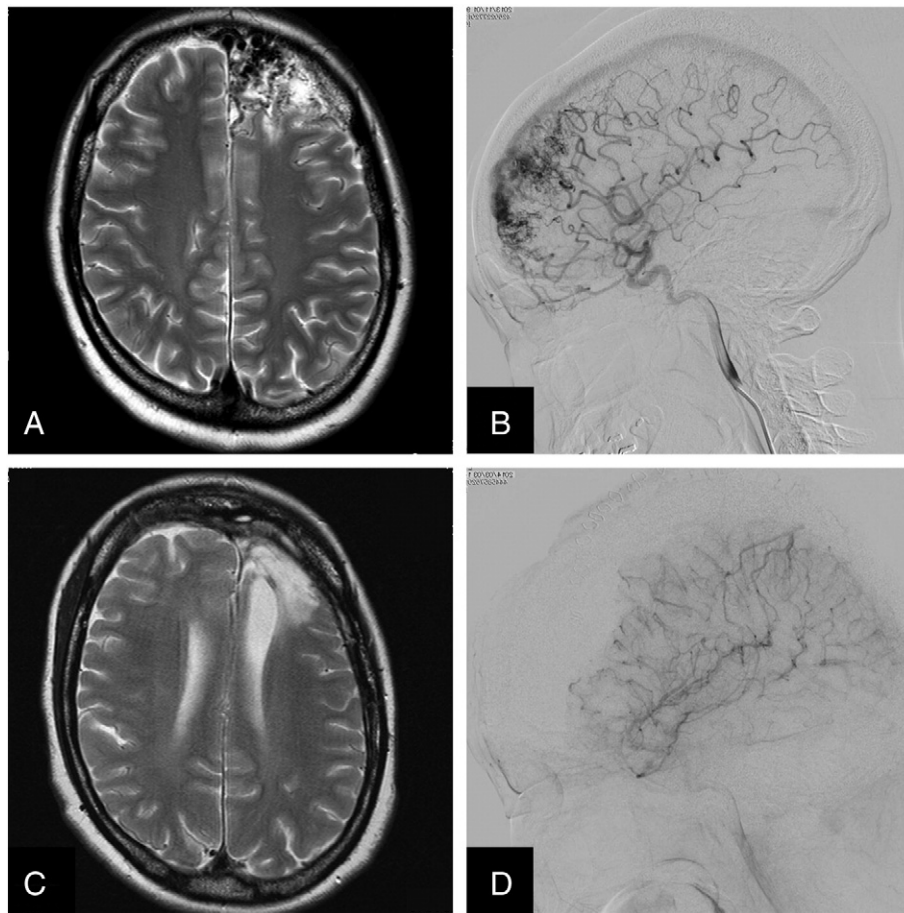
Comparative pictures of preoperative and postoperative imaging study. (A) Preoperative axial T2 weighted magnetic resonance imaging (MRI) study of the brain showing a 6-cm arteriovenous malformation (AVM) located in the left frontal lobe. (B) Preoperative digital subtraction 4-vessel angiogram (DSA) showing a large AVM nidus, which is fed by cortical branches of the anterior cerebral artery and the middle cerebral artery. The main drains are the ascending cortical veins draining into the superior sagittal sinus. Postoperative axial T2 weighted MRI (C) and postoperative DSA (D) showing total resection of the AVM.
